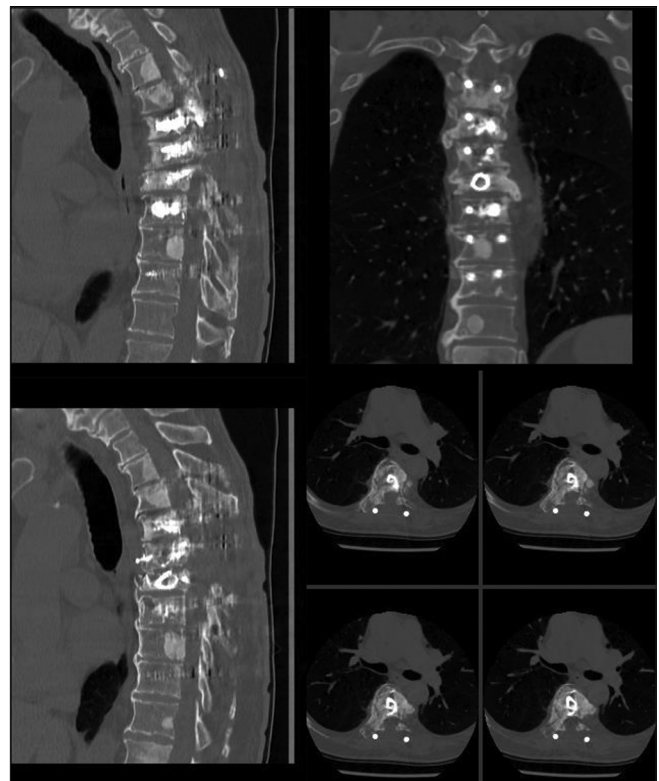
Computed tomography images at 6 months postoperative period in 73 years old with T7 metastatic spinal cord compression showing stent well incorporated in the vertebral body.
